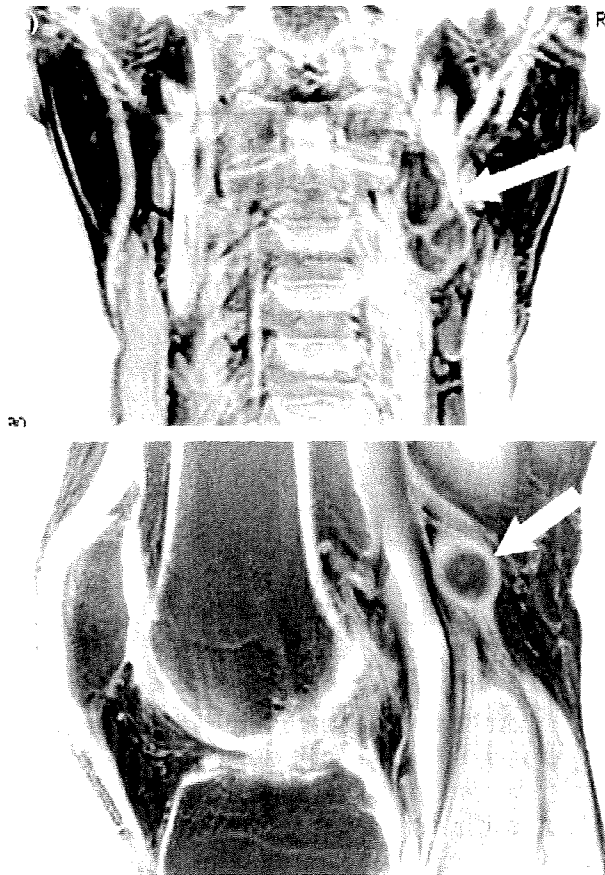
(a) T₁-weighted magnetic resonance image (MRI) of the left carotid space. (b) T₁-weighted MRI of the left knee shows an oval mass continuous to the nerve.
